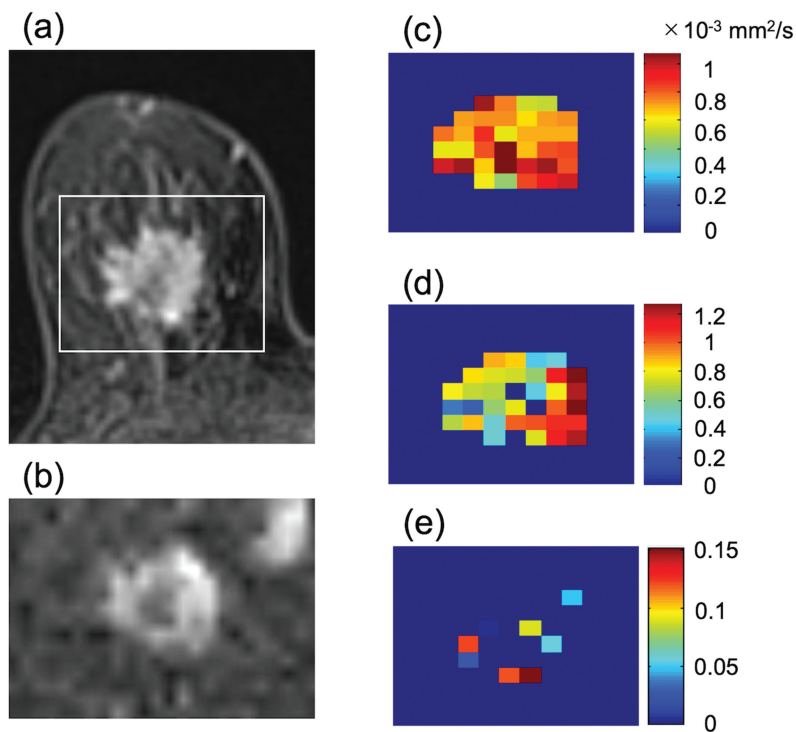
Images of a 77-year-old woman with invasive ductal carcinoma who developed pleural metastasis 5 years and 11 months after MR examination. (a) contrast-enhanced axial MR image, (b) DWI ($b = 1500 \text{ s/mm}^2$), (c) ADC_0 map, (d) K map, (e) f_{IVIM} map. The white rectangle on (a) shows the area covered by the parametric maps. (a) The mass lesion is heterogeneously enhancing. (b) The lesion shows heterogeneously high signal intensity on DWI. (c) ADC_0 map shows low values throughout the lesion with a mean value of $0.9 \times 10^{-3} \text{ mm}^2/\text{s}$. (d) The mass shows relatively high mean K values (1.0) with heterogeneous distribution. (e) f_{IVIM} map shows low values throughout the lesion with a mean value of < 0.01 . ADC, apparent diffusion coefficient; DWI, diffusion-weighted imaging; f_{IVIM} , flowing blood volume fraction; K, kurtosis.
